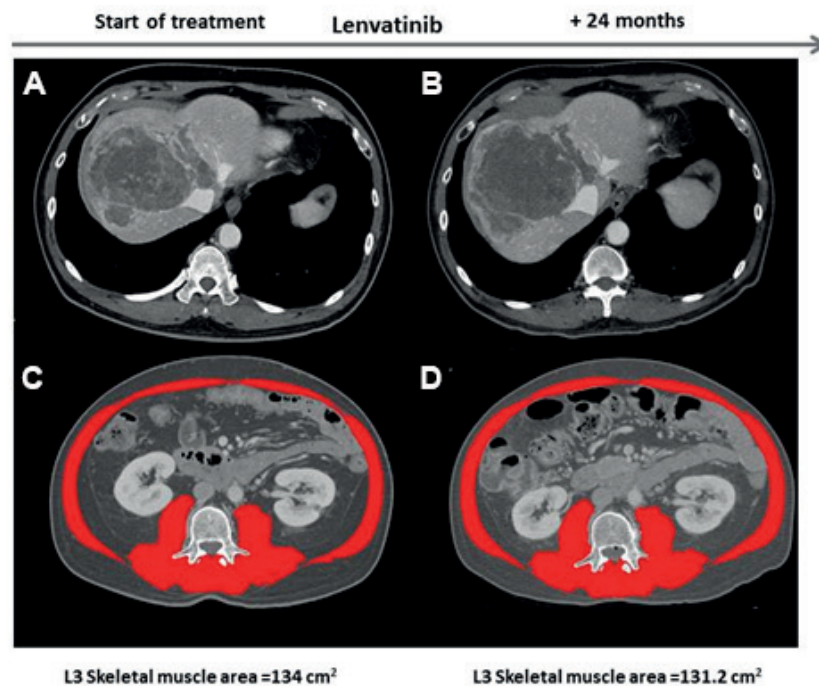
Skeletal muscle area (SMA) during chemotherapy with lenvatinib (Case 1). Panels A and B: CT scans of the liver at baseline (A) and at 24 months of chemotherapy (B), showing substantially stable disease. Panels C and D: CT scans of the skeletal muscle at the L3 level at baseline (C) and at 24 months of chemotherapy (D).
